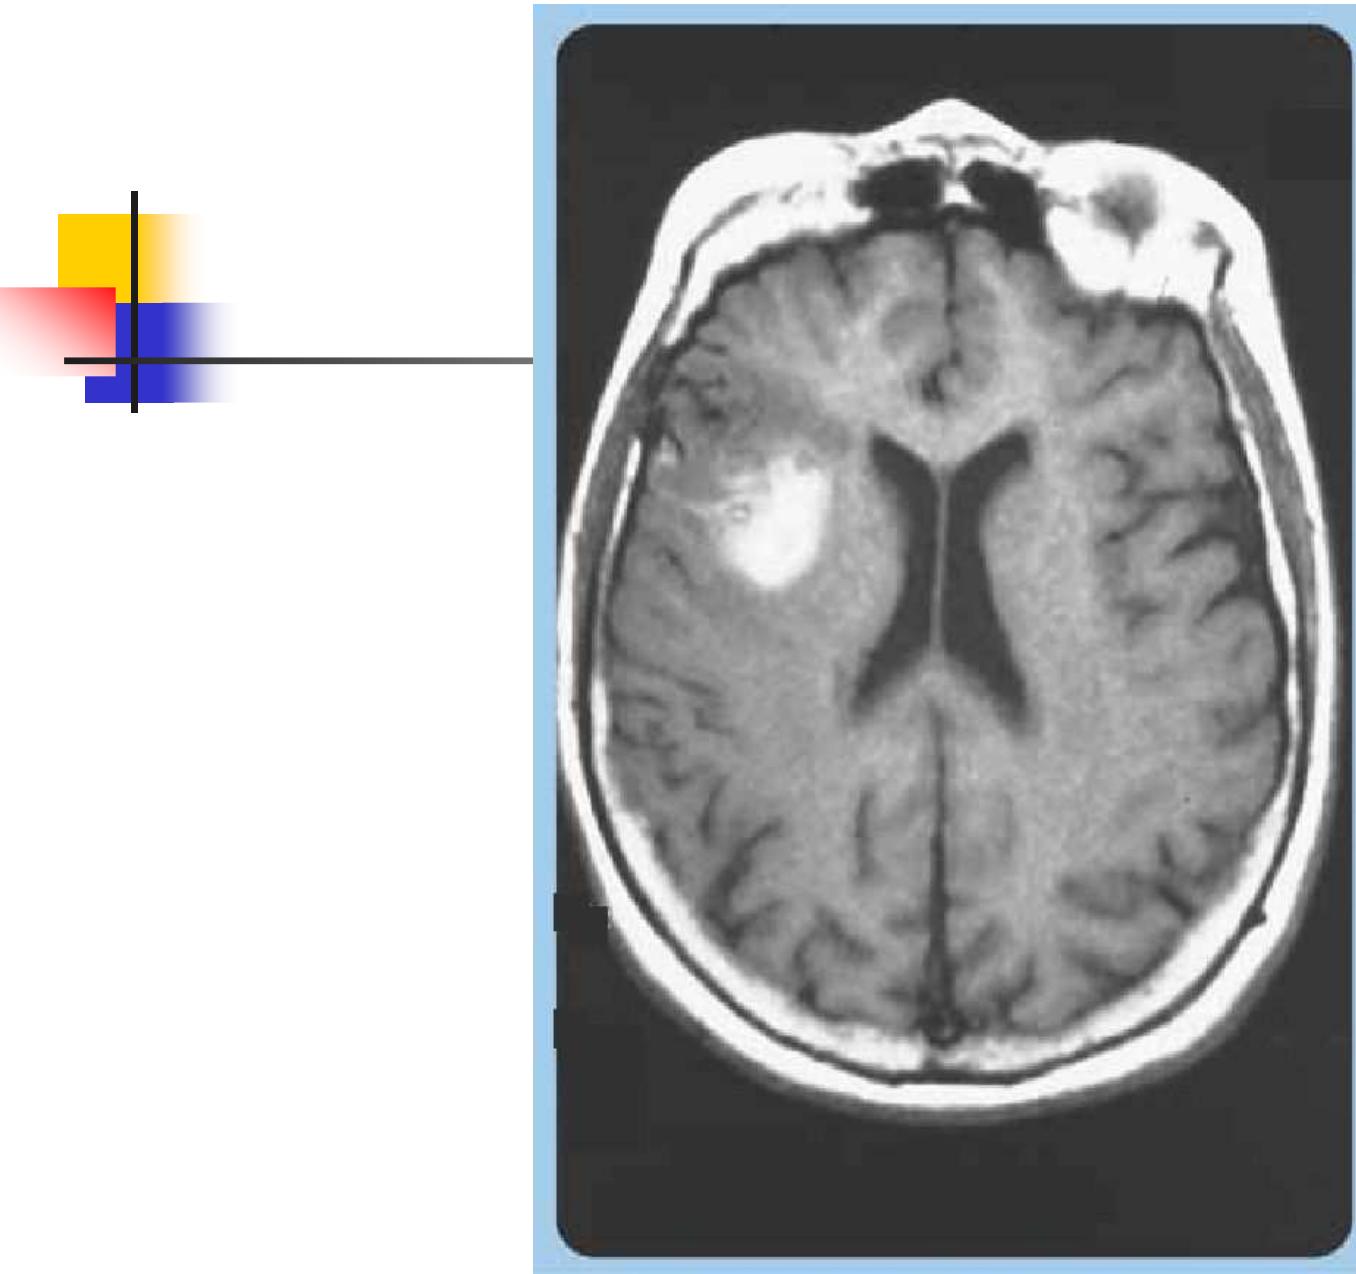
Brain magnetic resonance imaging of a sylvian cardioembolic hemorrhagic infarction (T1-weighted spin echo sequences).
